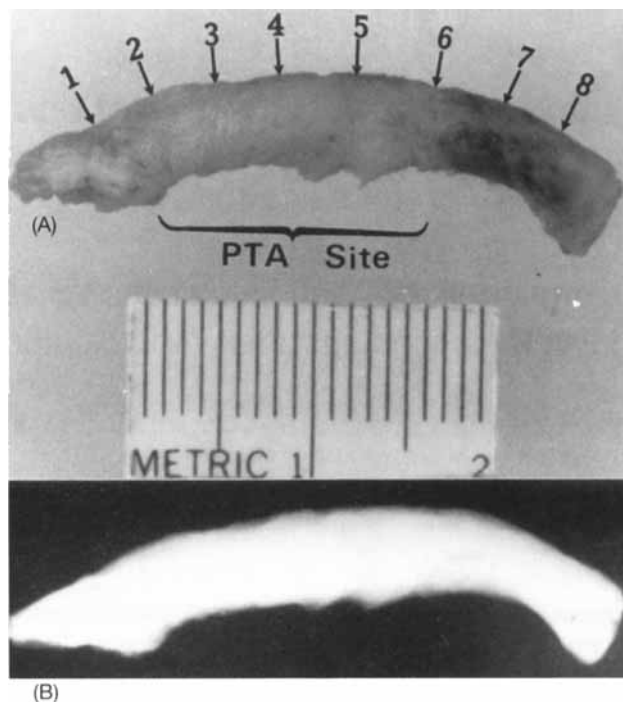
Excised saphenous vein conduit following transluminal balloon angioplasty (PTA). (A) Sites of transverse sectioning. The numbers correspond to serial sections seen in Figure 2. (B) Radiograph showing no calcific deposits. From Ref. 5 with permission.
